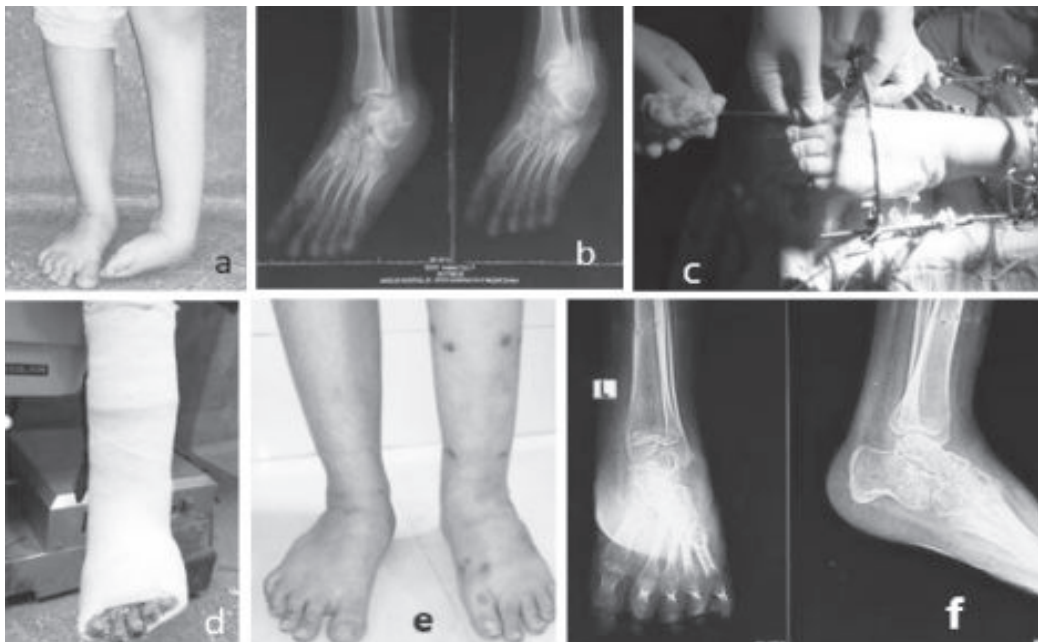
Representative images of an 8-year-old girl with a deformed left foot who has been treated previously for clubfoot. A preoperative photograph of the child standing showed severe talipes equinovarus remained on the left side after previous treatment (a). A preoperative radiograph showing the deformity of left foot (b). An external fixator was used to correct the deformity (c). Short leg full plaster after the procedure (d). The photograph shows that a plantigrade foot was achieved and the appearance and function of the left foot had been improved significantly after removing the frame (e). The postoperative radiograph showed that the deformity had been corrected and the foot bones had returned to a normal arrangement (f).
